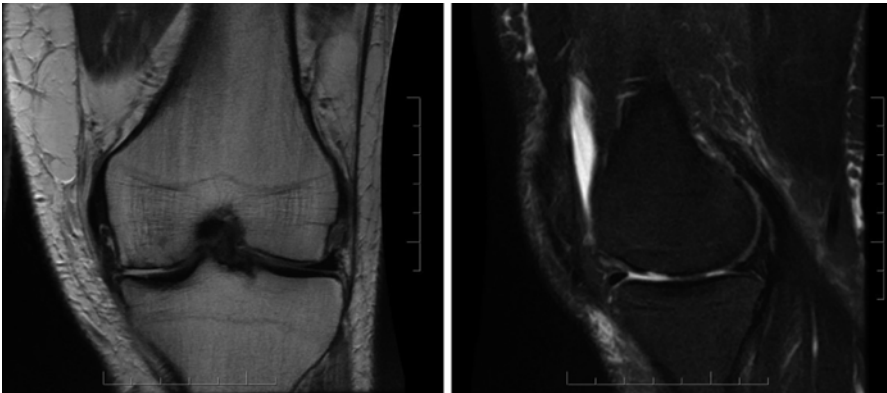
Representative coronal and sagittal cut from a left knee MRI (same patient as in Fig. 2.2) demonstrating severe degenerative changes in the medial compartment
